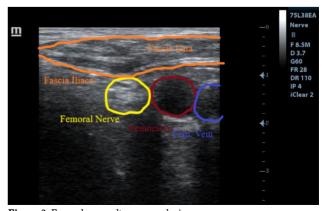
Femoral nerve ultrasonography image.
